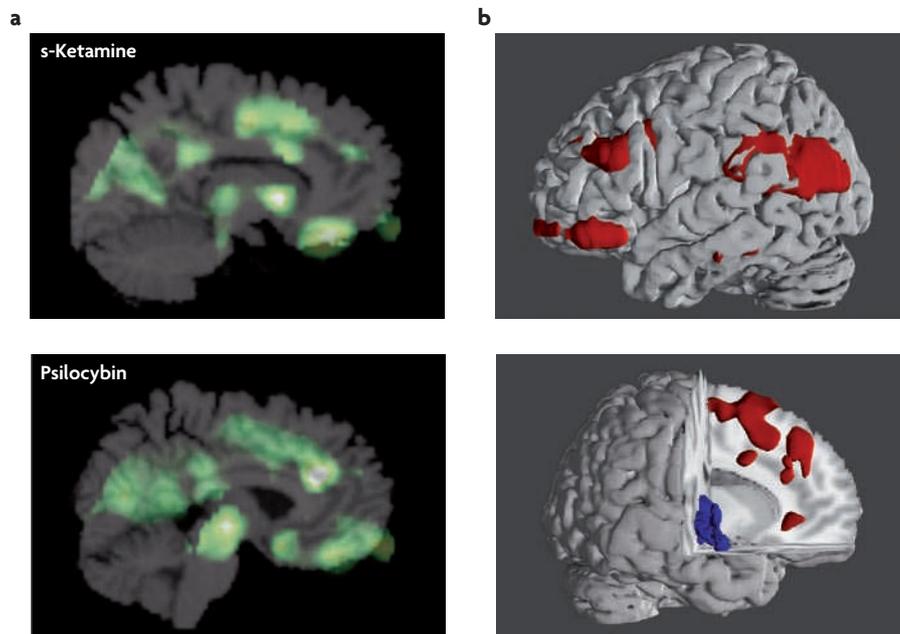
Brain activity patterns in psychedelic-induced states of consciousness. a | Brain imaging studies using ¹⁸fluorodeoxyglucose [¹⁸FDG] positron emission tomography (PET) revealed that moderate doses of s-ketamine (top) and psilocybin (bottom) in healthy volunteers increased neuronal activity. This is shown by changes in the cerebral metabolic rate for glucose (CMRglu) in the prefrontal cortex and associated limbic regions and in subcortical structures, including the thalamus^{107,109}. This similar prefrontal–limbic activation pattern supports the view that both classes of drugs have converging effects on a final pathway or neurotransmitter system. b | Recent [¹⁸FDG] PET brain imaging studies have demonstrated that the degree to which each of the psychedelic-induced key dimensions of altered states of consciousness (BOX 2) is manifested and correlated with functional alterations in cortical and limbic regions and subcortical structures, including the basal ganglia and thalamus. For example, the intensity of experience of the key dimension ‘oceanic boundlessness’ correlated with the s-ketamine- and psilocybin-induced activation (red) of a prefrontal–parietal network and the deactivation (blue) of a striato–limbic amygdalocentric network¹⁴⁹.
